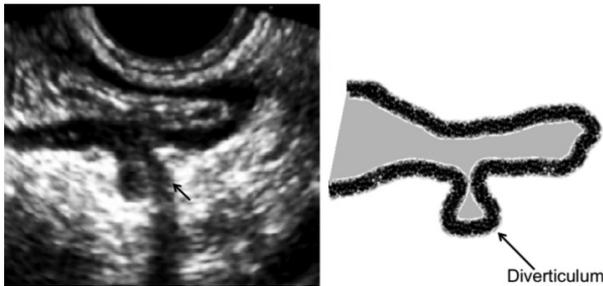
Transvaginal sonogram obtained with a 9-MHz endocavitary probe. It shows an uncomplicated diverticulum at the level of the sigmoid colon with adjacent acoustic shadowing (short arrow) secondary to the presence of a fecolith or air.
